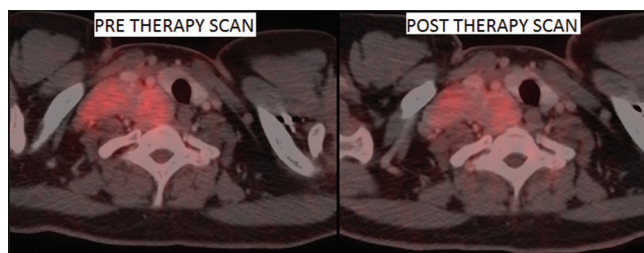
Case 1 – pretherapy and posttherapy positron-emission tomography/computed tomography scan image with mild fluorodeoxyglucose-avid right cervical lymph nodes. After treatment with rituximab and steroids, only a mild decrease in metabolic activity with no significant change in size is noticed
